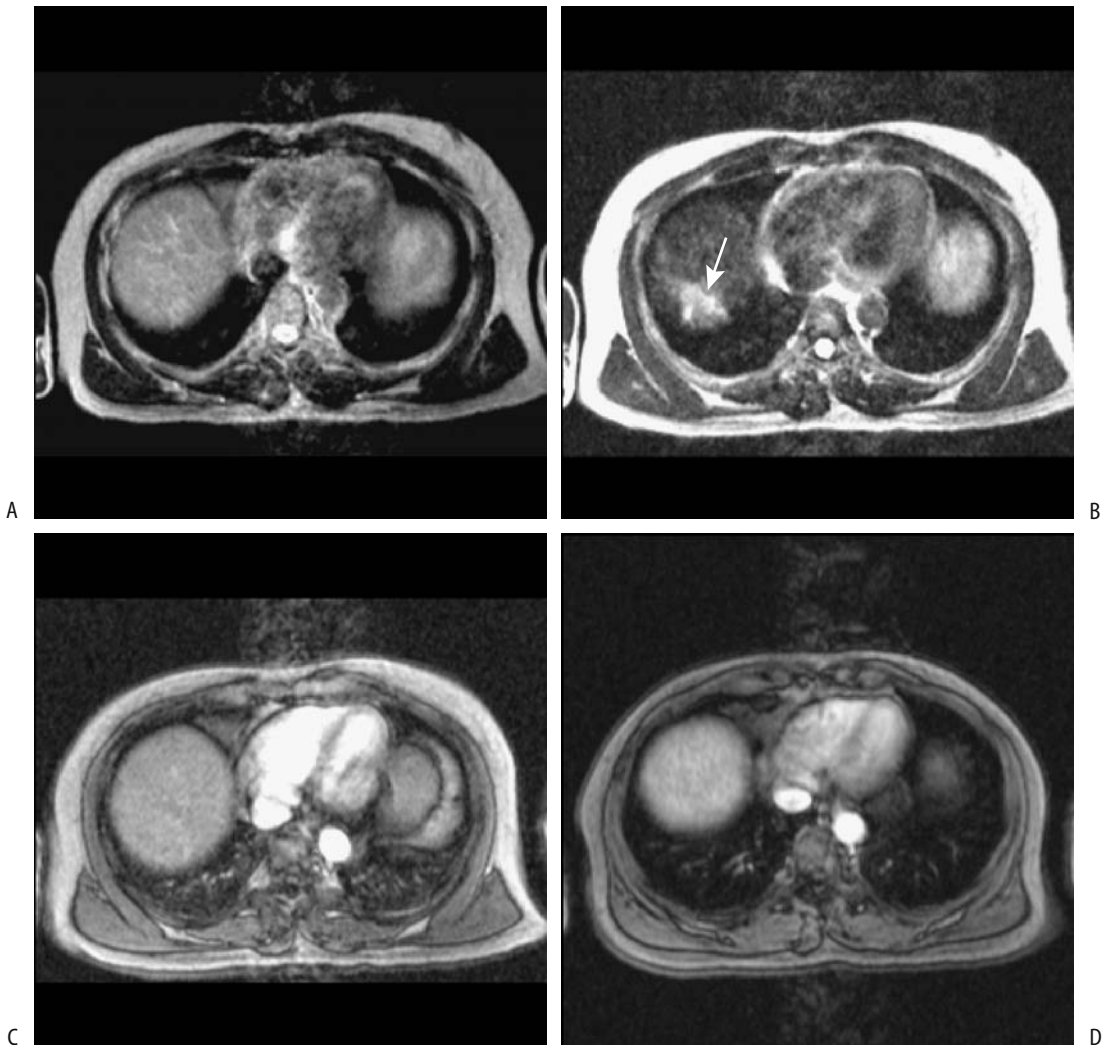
MR of a hepatocellular carcinoma in a cirrhotic liver. Nonenhanced long TR/long TE image (A), SPIO-enhanced long TR/long TE image (B), T1-weighted FLASH image 10 seconds after gadolinium (C), and T1-weighted FLASH image 40 seconds after gadolinium (D). This tumor (arrow in B) was identified only on SPIO-enhanced images. (Source: Ward J, Guthrie JA, Scott DJ, et al. Hepatocellular carcinoma in the cirrhotic liver: double-contrast MR imaging for diagnosis. *Radiology* 2000 216:154–162, with permission from the Radiological Society of North America.)
